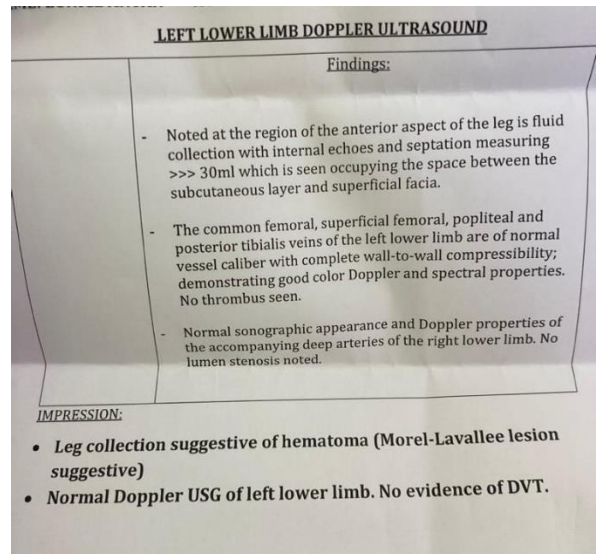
An image of the ultrasound findings of the leg of our index patient
